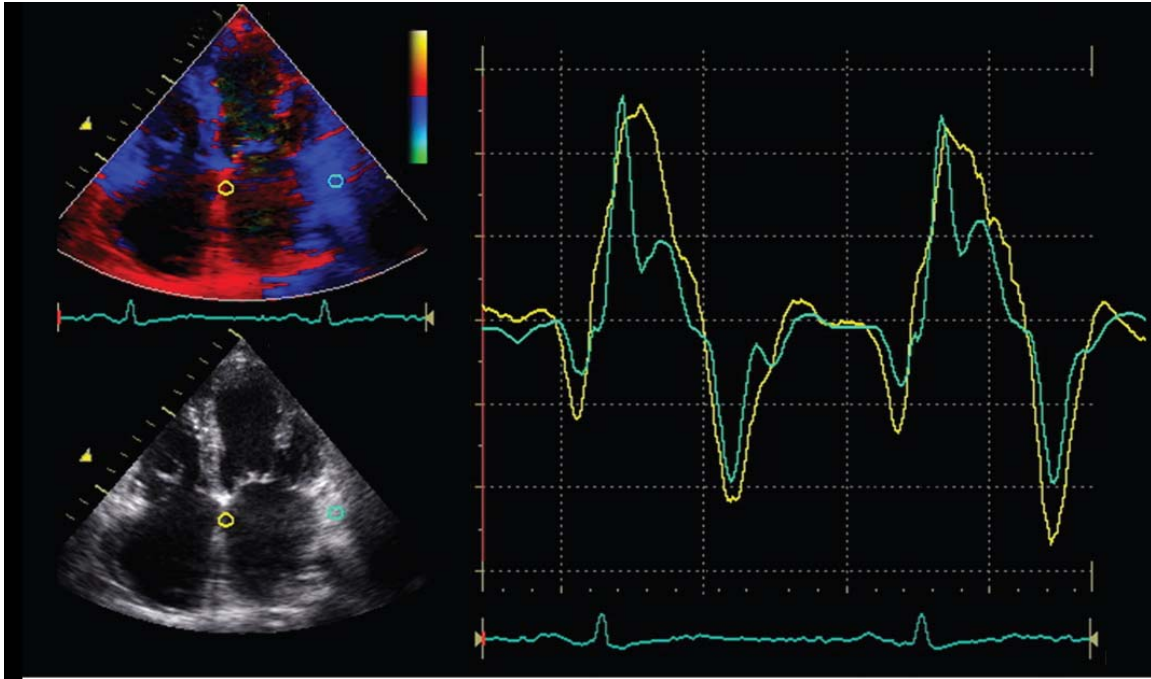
Color-coded tissue Doppler imaging in the apical four-chamber view for the assessment of regional Left Atrial function. The samples are placed in the basal atrial septum (yellow curve) and the basal atrial lateral wall (green curve). From the myocardial velocity curves, peak systolic and diastolic velocities can be assessed. Early diastolic filling is indicated by E' and late diastolic filling is indicated by A'.
